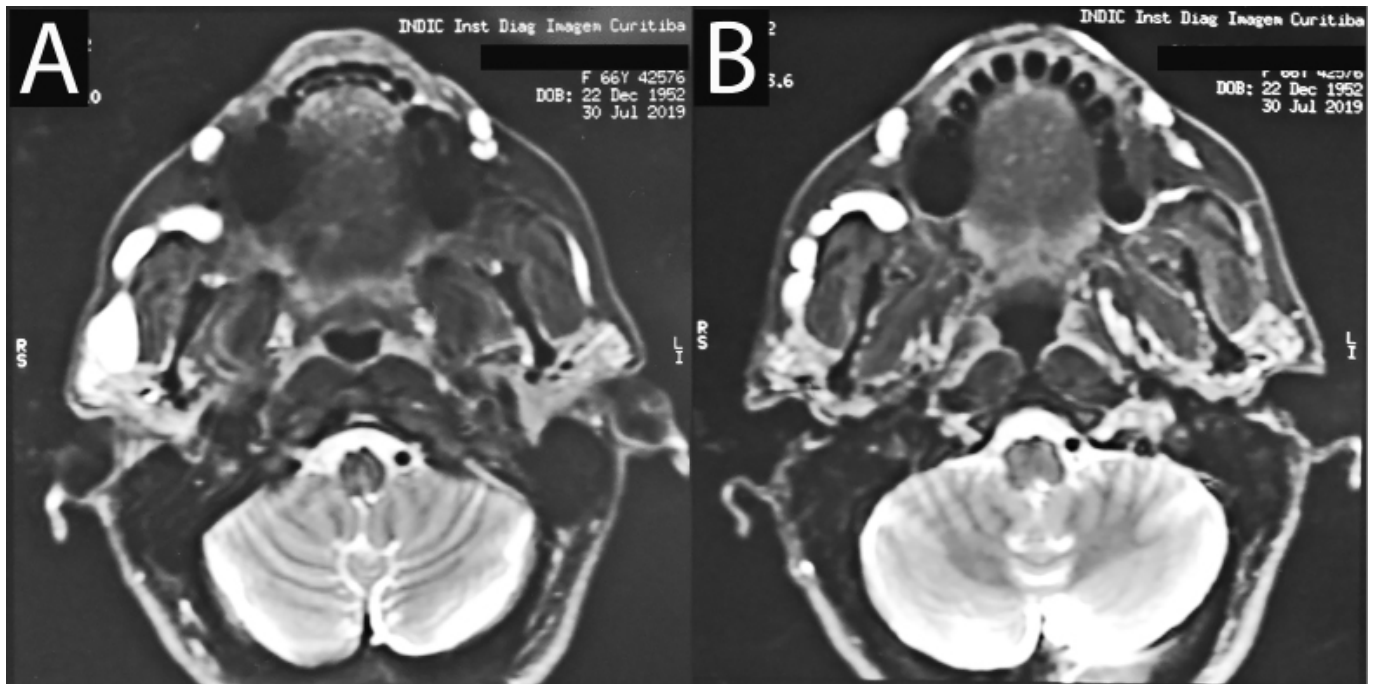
Magnetic resonance sialography 9 months after sialoendoscopy. (A) Axial section (T2-weighted image) stenosis, ectasia, and sialoceles of the right parotid duct. (B) Axial section (T2-weighted image) shows stenosis of the right parotid duct.
